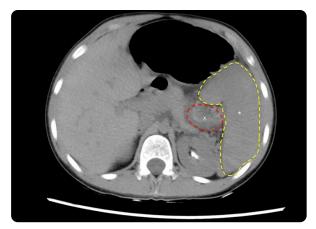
CT portal phase. The vascular swirl sign (X) is observed, the vascular pedicle and the splenic hilum persist without contrast enhancement, as well as the spleen (*), the liver density of 110 HU is mentioned, compared to that of the spleen of 43 HU, with a liver-spleen density ratio higher than 2.
